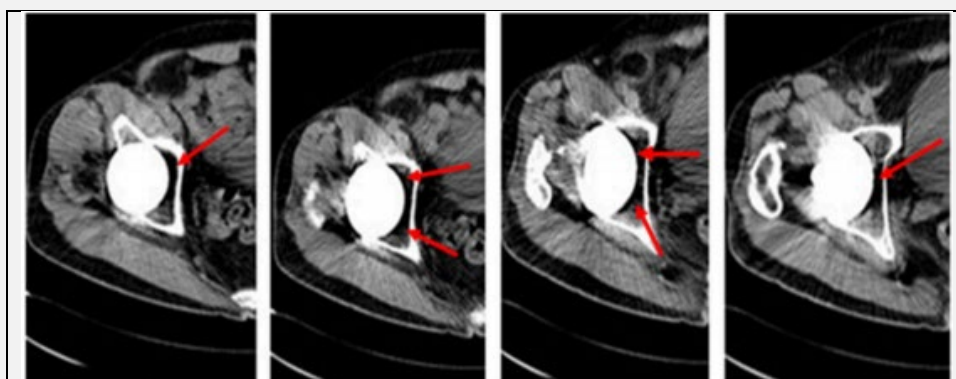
Computed tomographic scan of the right hip 12 years after surgery, revealing local osteolysis around the acetabular component.
